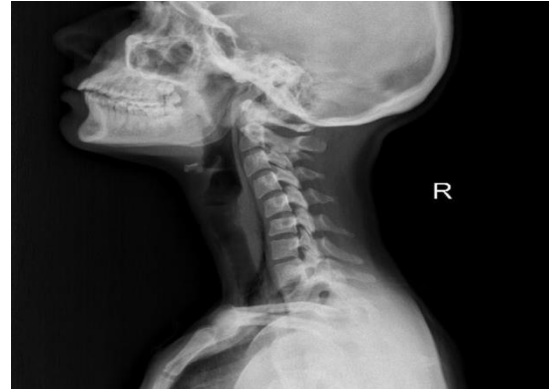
Air in the cervical X-ray
